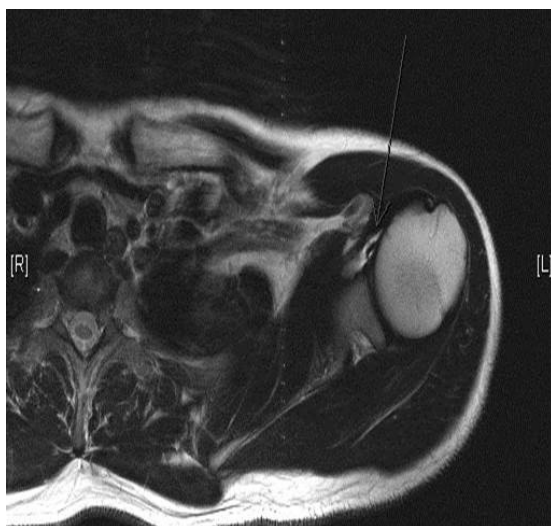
Axial (A) and sagittal (B) sections of magnetic resonance images of the left shoulder, demonstrating fluid collection below the coracoid process.
